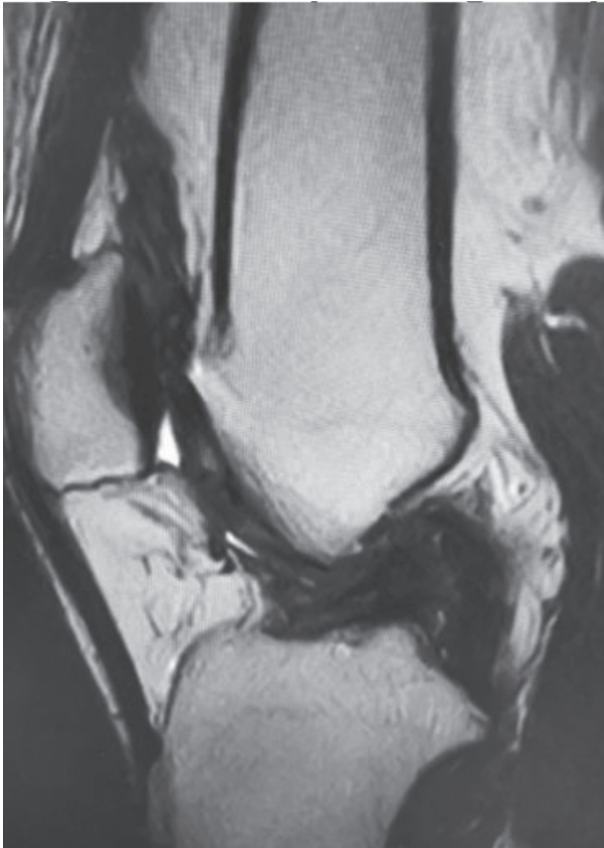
MRI of pathologic suprapatellar synovial plica
